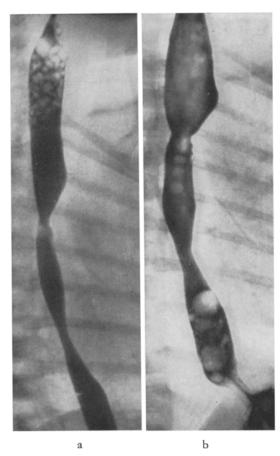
Another patient with a stenosis in the lower oesophagus. The roentgen examinations were made 2 weeks (a) and 6 weeks (b), respectively, after operation for oesophageal atresia and tracheo-oesophageal fistula
